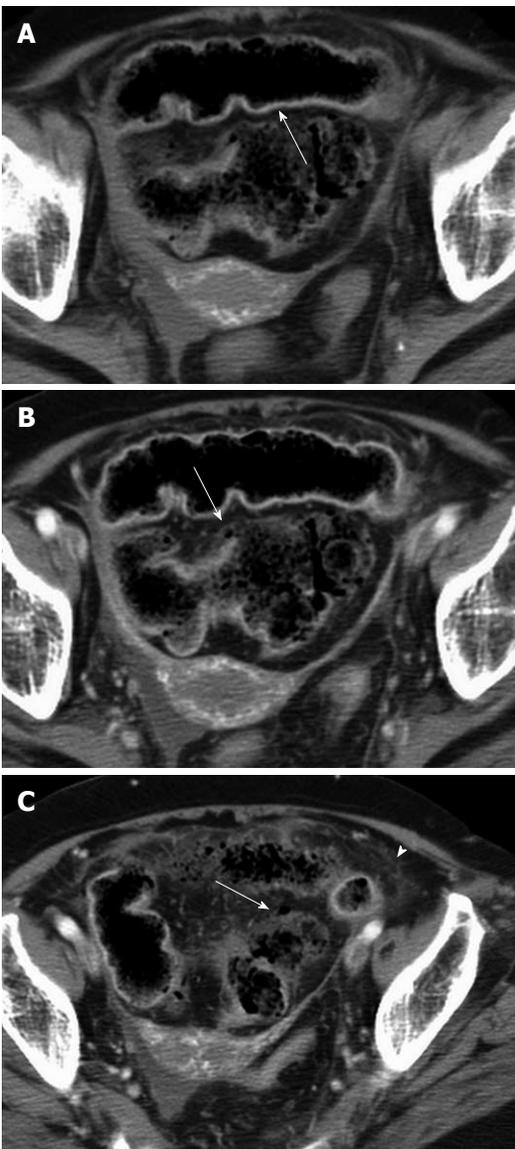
An 80-year-old woman (patient 5) with perforation of the necrotic stercoral colitis at the sigmoid colon. A: An unenhanced computed tomography (CT) scan reveals dense mucosa (arrow) conforming to the colon wall; B: An enhanced abdominal CT scan reveals discontinuation of the colonic mucosa (arrow) suggesting perfusion defect; C: A small air bubble abutting the damaged colon (arrow) and increased pericolic infiltration (arrowhead) can be seen.
